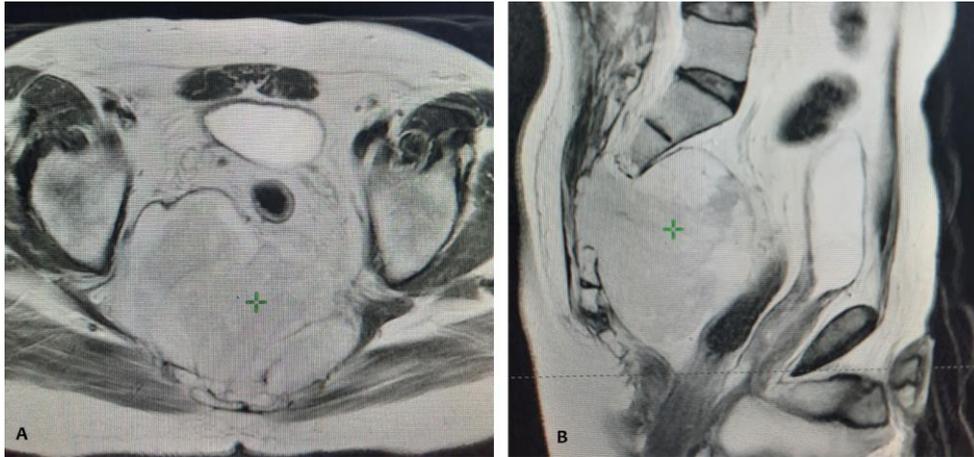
Axial slice (A) and sagittal slice (B) T2 weight pelvic MRI, showing sacral mass of polylobed aspect, lysing the anterior cortex of the sacrum and pushing the rectum forward
